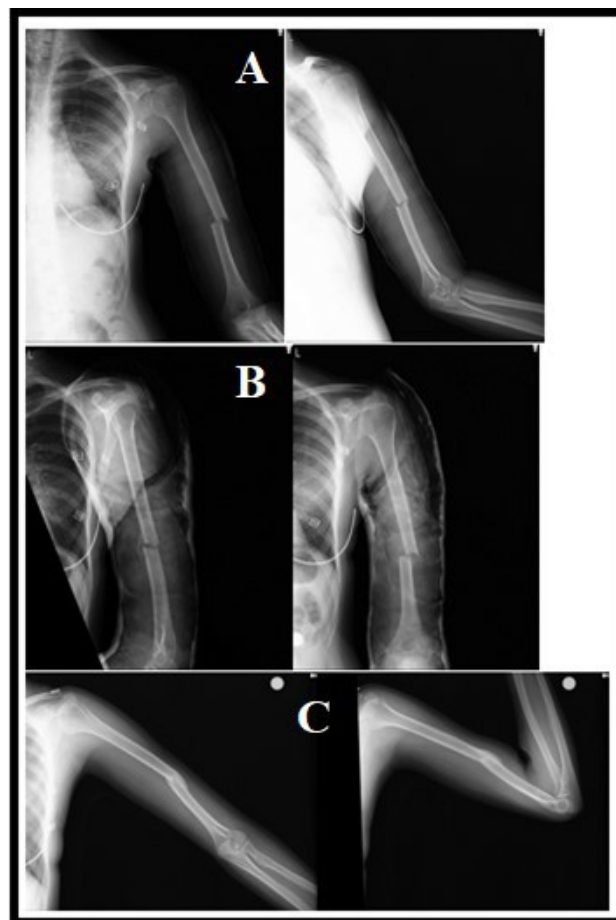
Outpatient control radiographies (A: initial radiographies, B: first month radiographies, C: first year radiographies)
